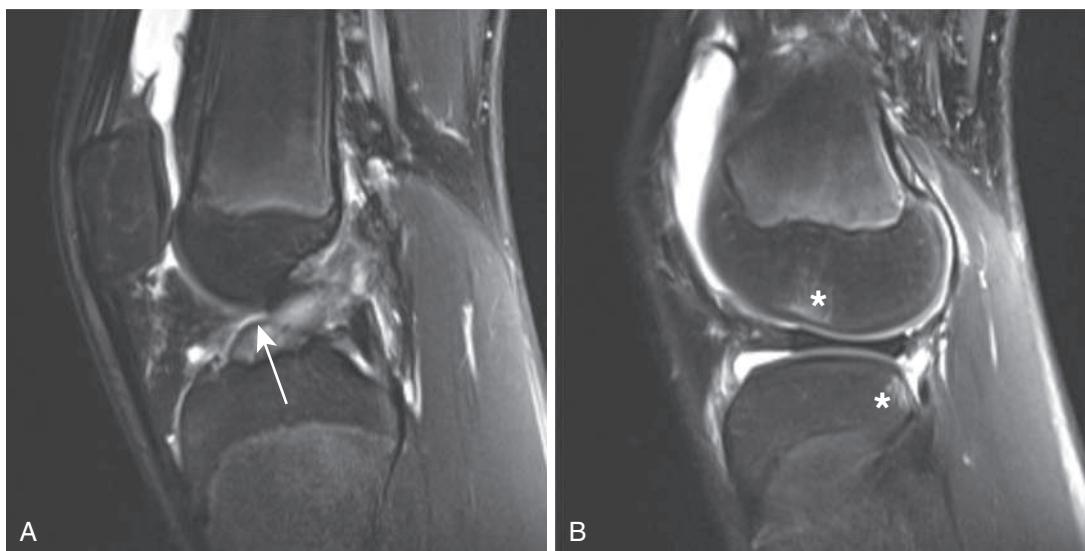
A 14-yr-old female with full-thickness anterior cruciate ligament (ACL) tear. A, A T2-weighted fat-suppression sagittal image through the center of the knee demonstrates a full-thickness tear of the ACL with a folded stump near the tibial attachment. (arrow). B, A T2-weighted fat-suppression sagittal image through the lateral compartment demonstrates the characteristic kissing contusion pattern in the distal femoral condyle and posterior tibial plateau related to the anterior pivot shift that occurs during the ACL injury (asterisks).
